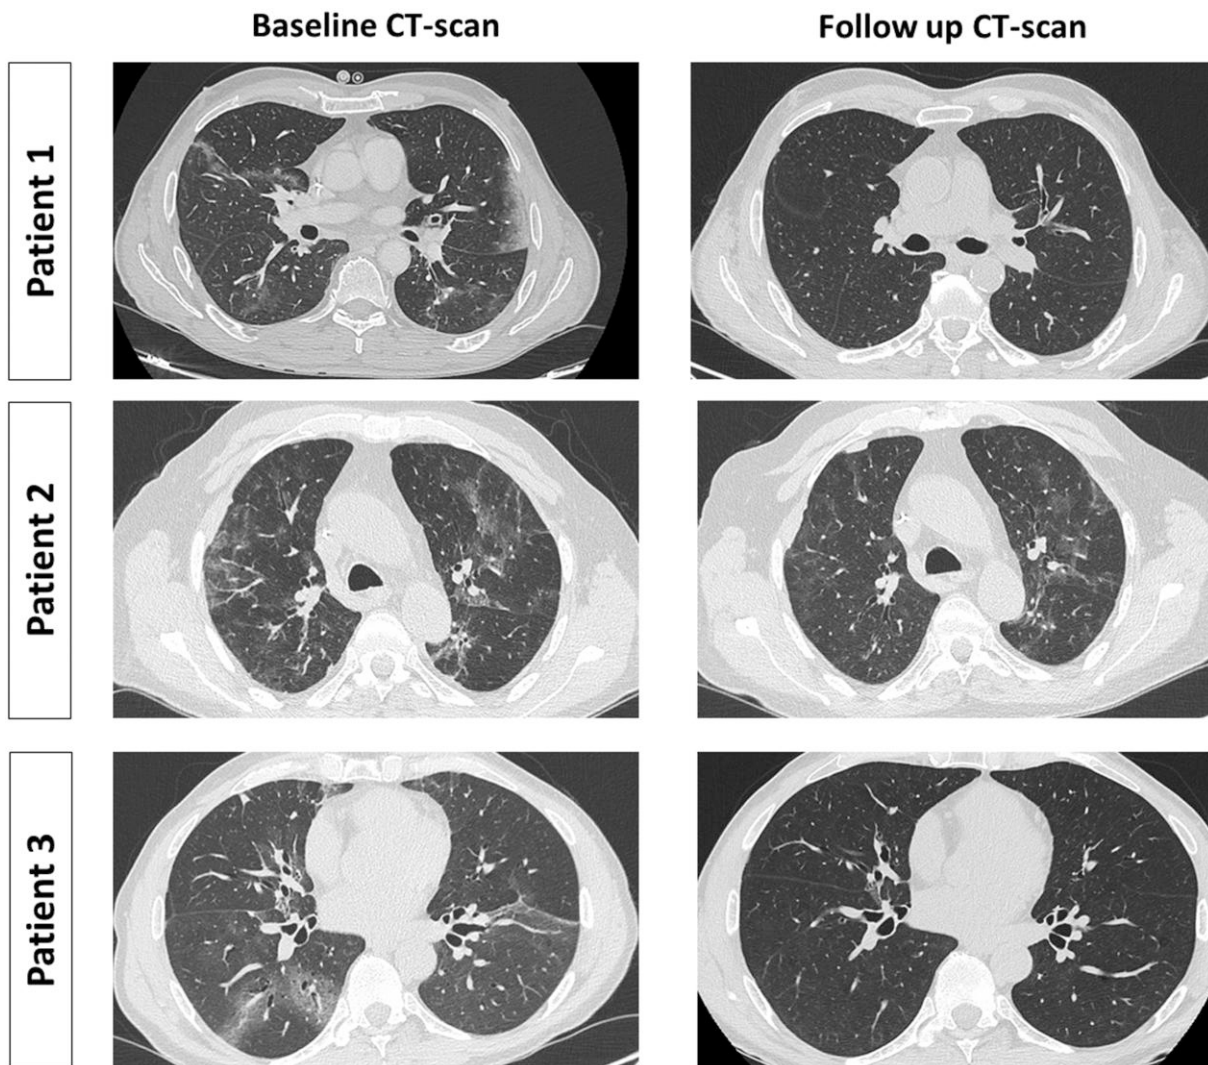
Comparison of CT scan findings pre- and post-treatment with nirmatrelvir/ritonavir. Follow up CT scan performed 1 month after treatment conclusion showed complete resolution of GGOs in Patient 1 and Patient 3, and significant improvement in Patient 2. Radiological findings were consistent with the successful clinical response to antiviral drugs in all three cases.
